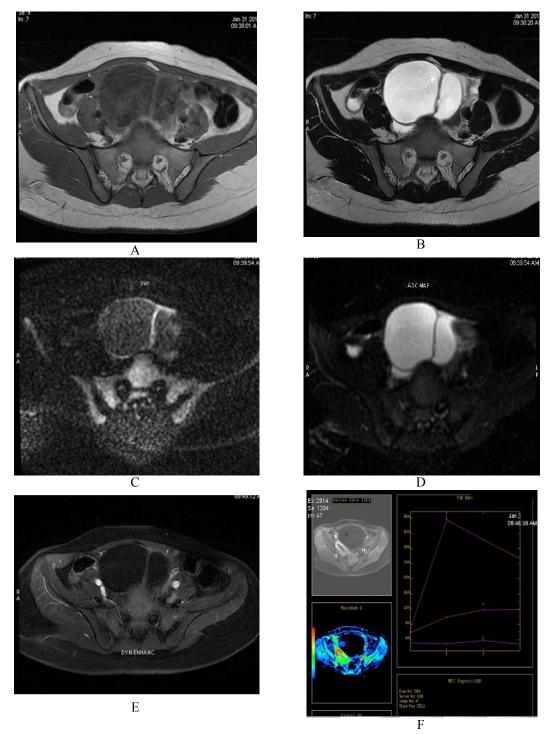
(A-G): Malignant high grade serous carcinoma in a 52 year-old postmenopausal woman (a&b) Axial T1 and T2-weighted images show bilocular adenxial cyst at left ovary with fluid signal intensity with irregular septum (c) Axial T1-weighted fat-suppressed dynamic image, obtained at 0 seconds post-contrast shows intense early peripheral and septal enhancement. ROIs are drawn over enhancing areas and adjacent myometrium (d) Graph shows the dynamic contrast-enhanced time-intensity curves, which indicate that wall and septum demonstrate greater and more, rapid early enhancement than myometrium (e) Diffusion-weighted (b=1000 sec/mm2) shows that enhanced periphery and septum demonstrates restricted diffusion with high signal intensity (arrows).(f,g) Corresponding ADC map shows that enhanced areas demonstrate low signal intensity. These criteria highly suggest malignancy.
